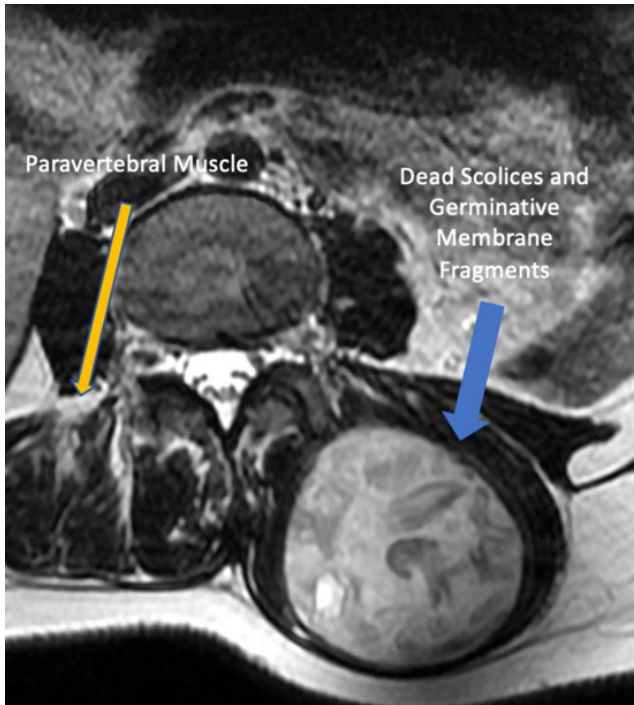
The CE3b hydatid cyst, which is situated in the paravertebral region on T2-weighted sagittal section MRI, contains daughter vesicles that are clearly hyperintense on T2A and contain heterogeneous hypointense fragments in the lower part of the cyst
